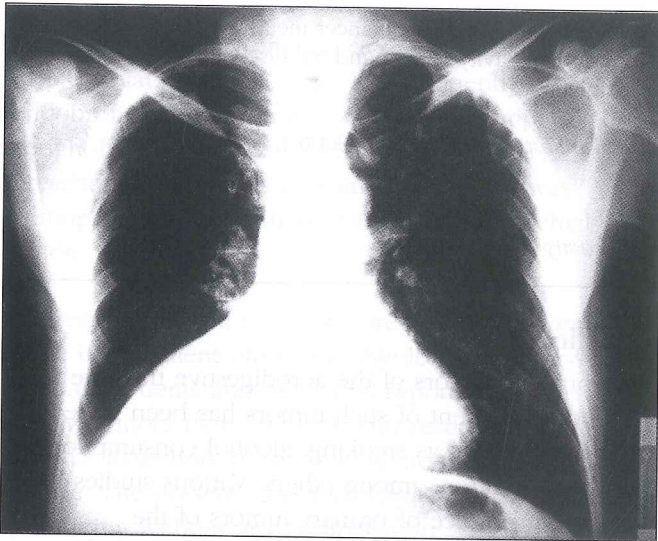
Chest X-ray on admission. Right lower lobe atelectasis was present.
